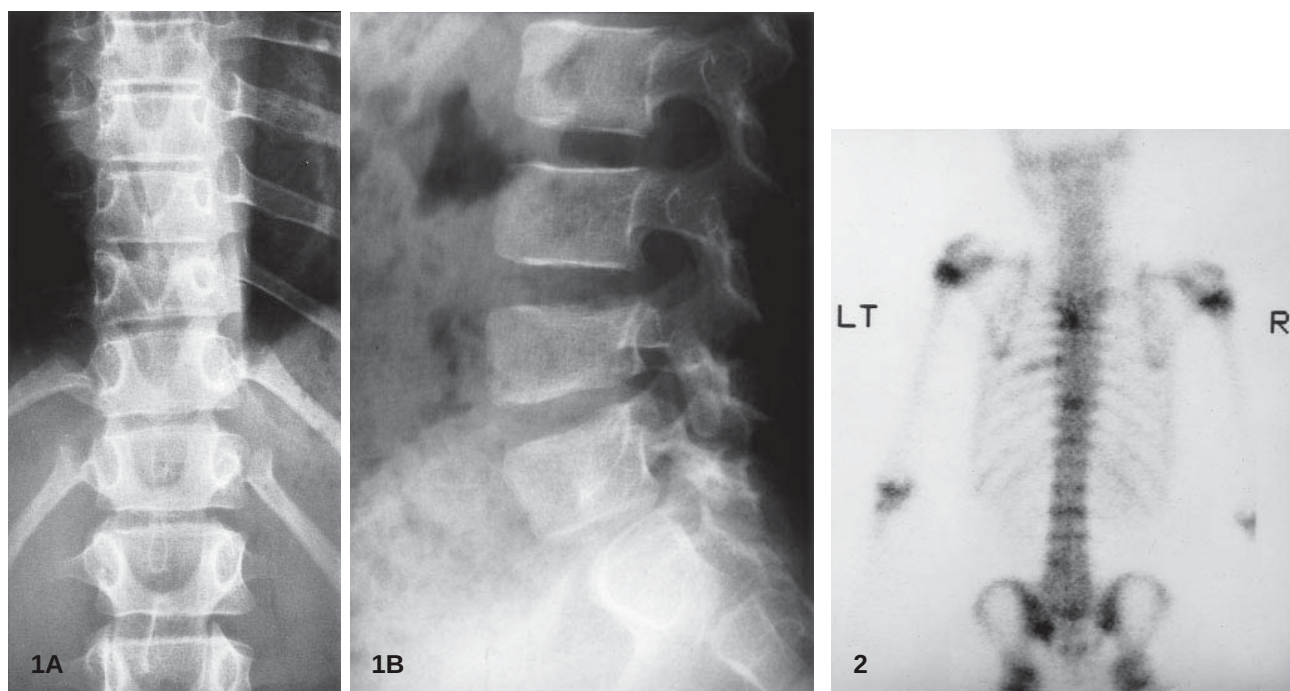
Case 1. A Anteroposterior radiograph of the lower thoracic spine demonstrating collapse of T10. B Lateral radiograph of the lumbar spine showing reduced height of L5 (the patient has six lumbar vertebrae)
